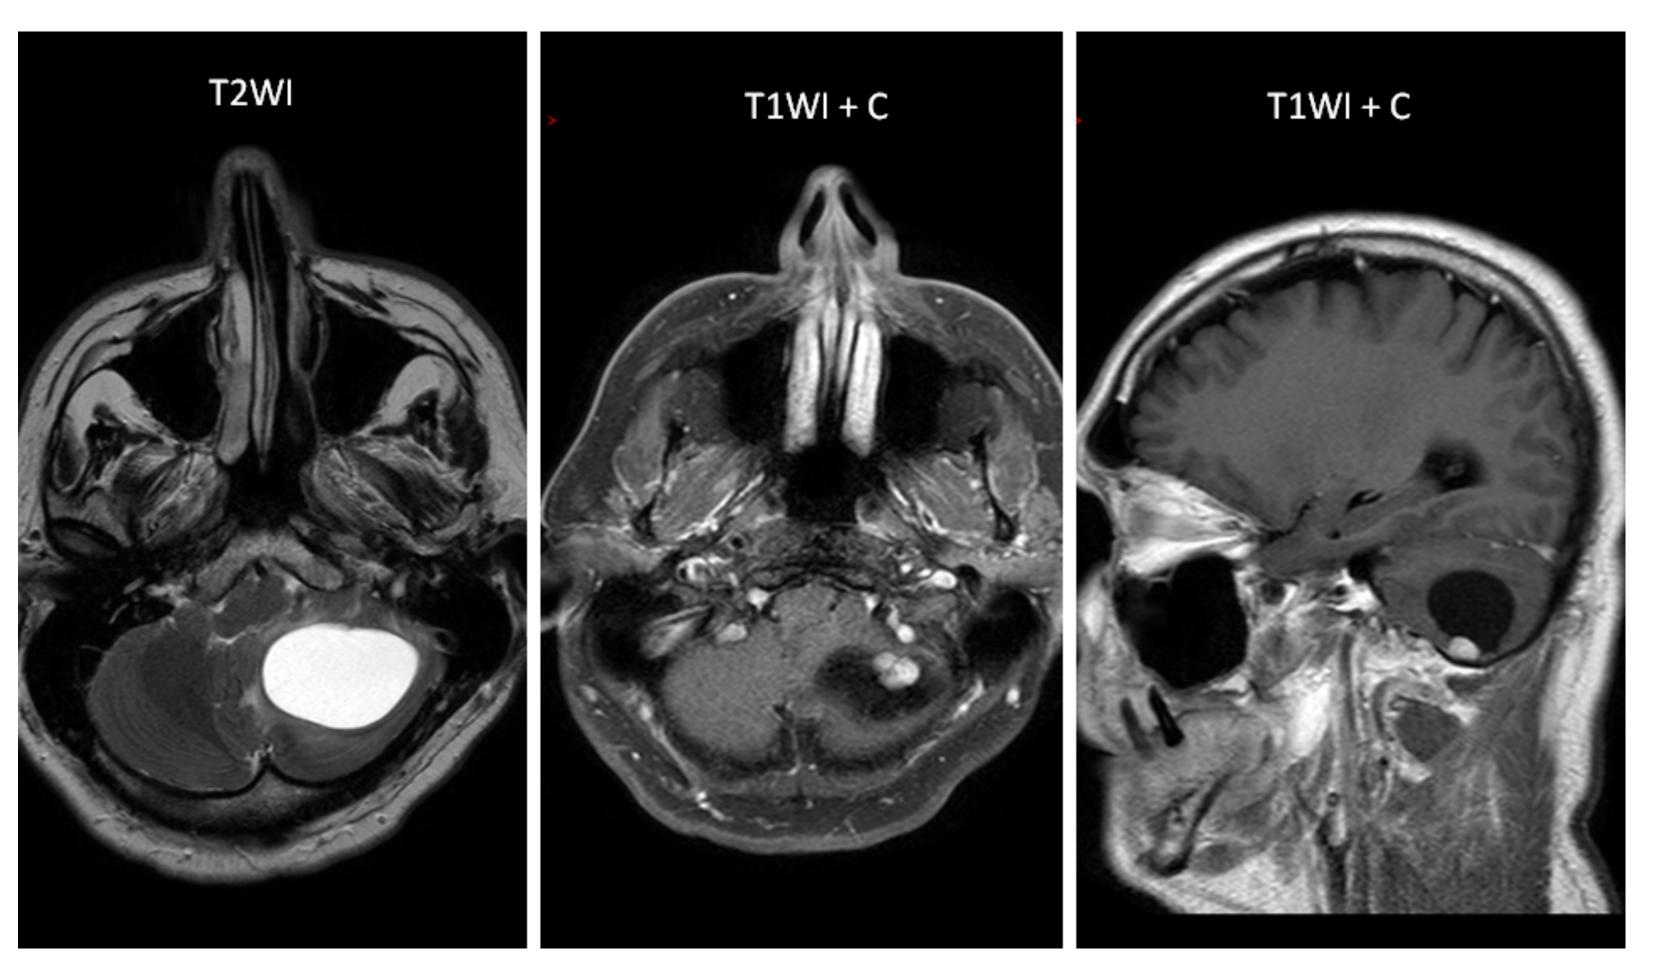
Courtesy of Leung RS, Biswas SV, Duncan M, Rankin S. Imaging features of von Hippel-Lindau disease. Radiographics. 2008 Jan-Feb;28(1):65-79; quiz 323. doi: 10.1148/rg.281075052. PMID: 18203931
